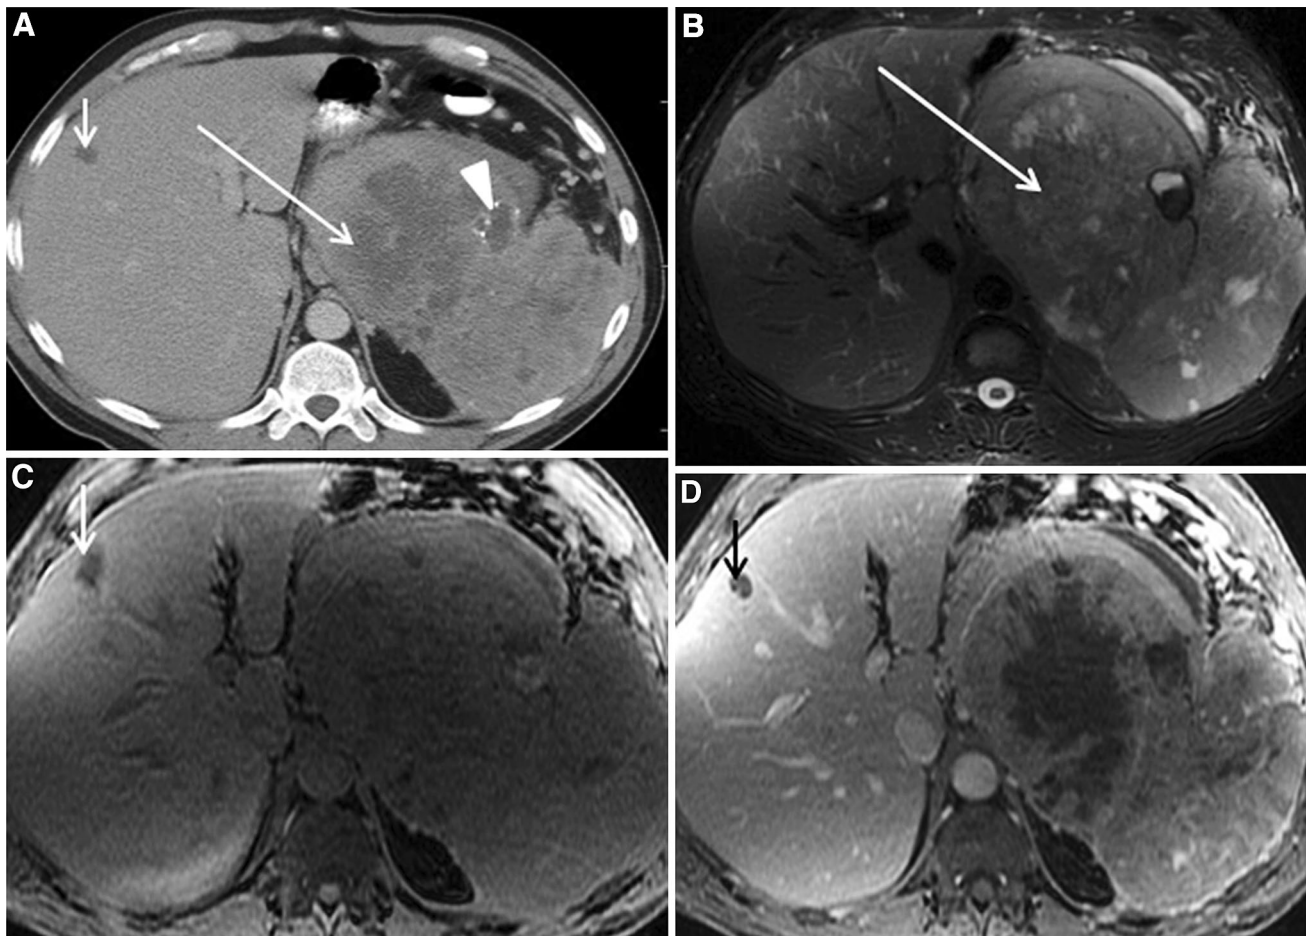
Angiosarcoma. 53-year-old man with abdominal fullness, nausea, and vomiting. A Axial contrast enhanced CT shows a large, heterogeneous mass (*long arrow*) arising from the spleen with internal low attenuation foci (likely representing necrosis and/or hemorrhage) and calcifications (*arrowhead*). B Axial T2-weighted gradient echo image shows a corresponding heterogeneous mass (*long arrow*) with areas
